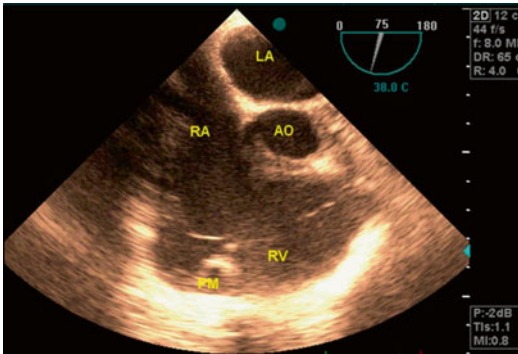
Transesophageal echocardiography in RV inflow-outflow imaging of the same patient reveals that all of the TV chordae tendineae are attached to a single dominant papillary muscle. *LA* left atrium, *RA* right atrium, *AO* aorta, *RV* right ventricle, *PM* papillary muscle
